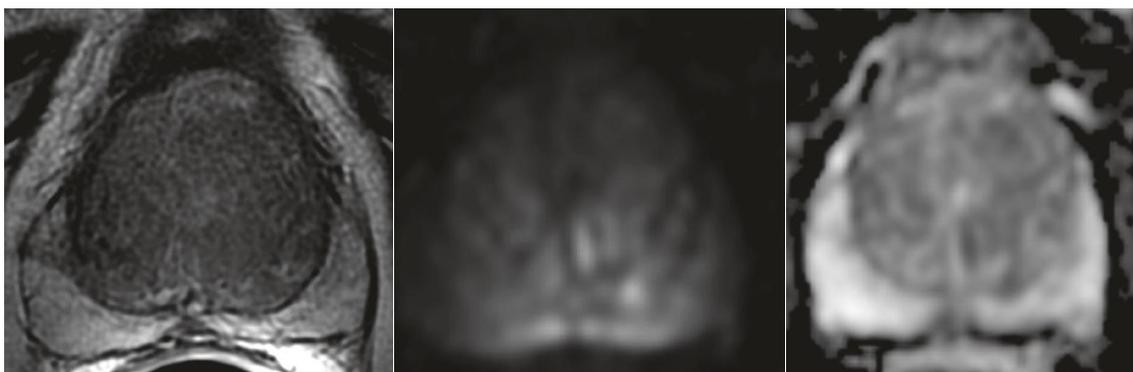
PI-RADS 1 category in PZ and TZ. First, axial T2WI. Second, b1400 DWI. Third, ADC map, without any abnormality on DWI/ADC map in the PZ and homogenous intermediate signal intensity of the TZ on T2WI. Obtained from (12).
